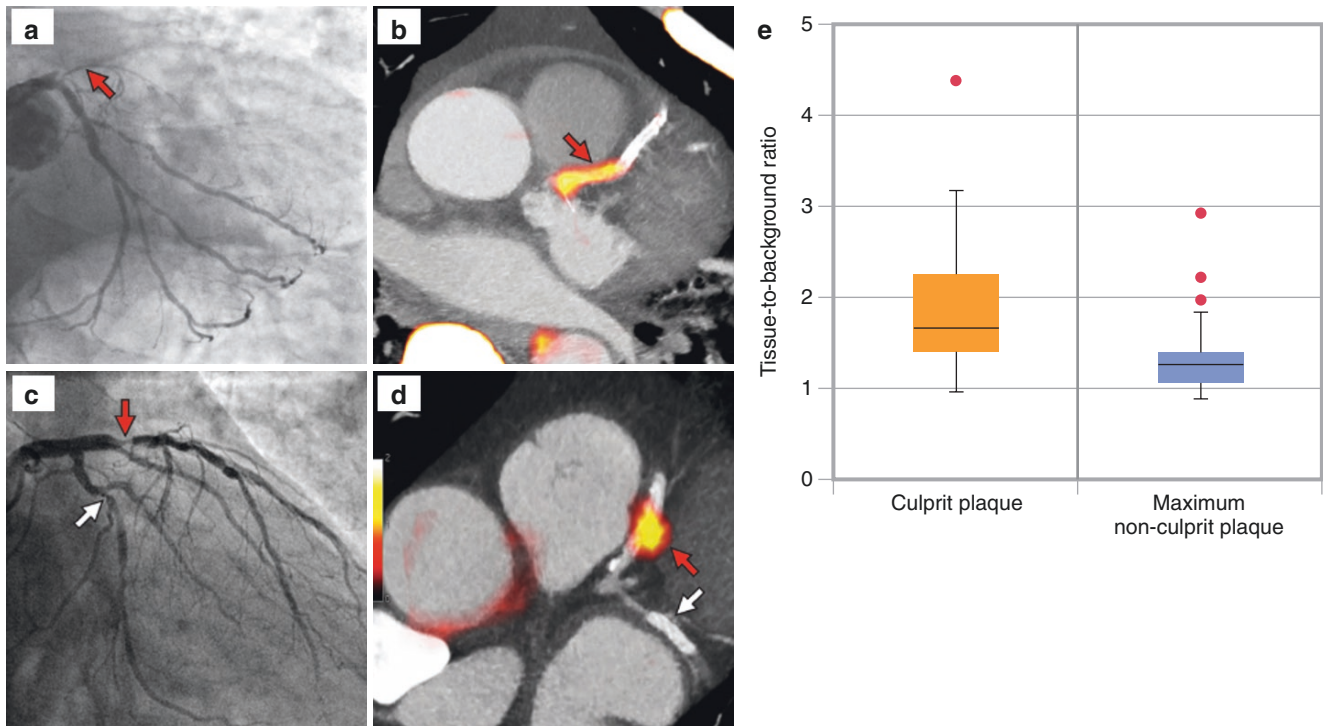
Increased NaF uptake in coronary artery culprit lesions. PET-CT imaging, using the tracer NaF, was performed in individuals with recent myocardial infarction. *Red arrows* in coronary arteriograms of two representative patients (a) and (c) show culprit lesions in the left anterior
